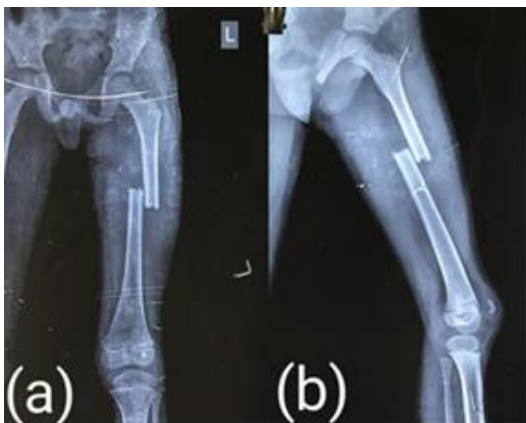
Preoperative radiograph: (a) Antero-posterior view and (b) Lateral view
